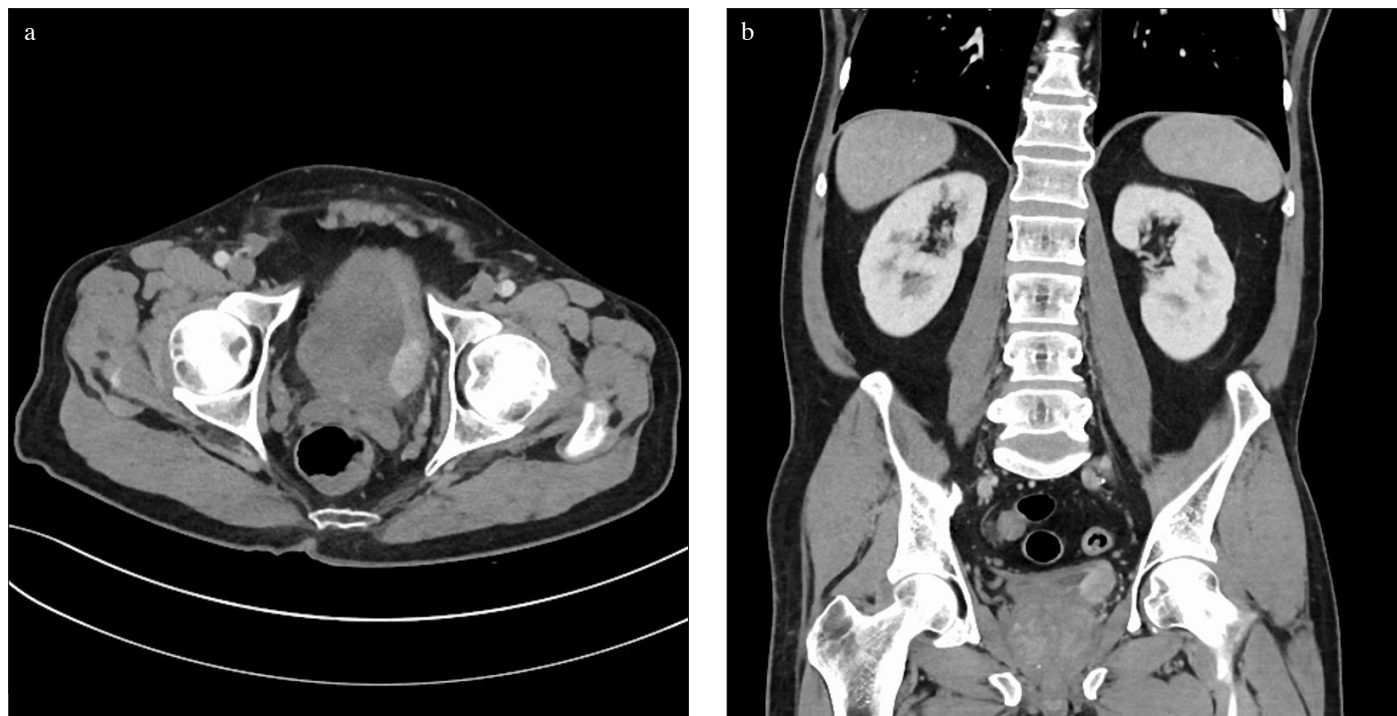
a, b. Computed tomography image showing the bladder tumor on the posterolateral wall. (a) Axial section. (b) Coronal section
